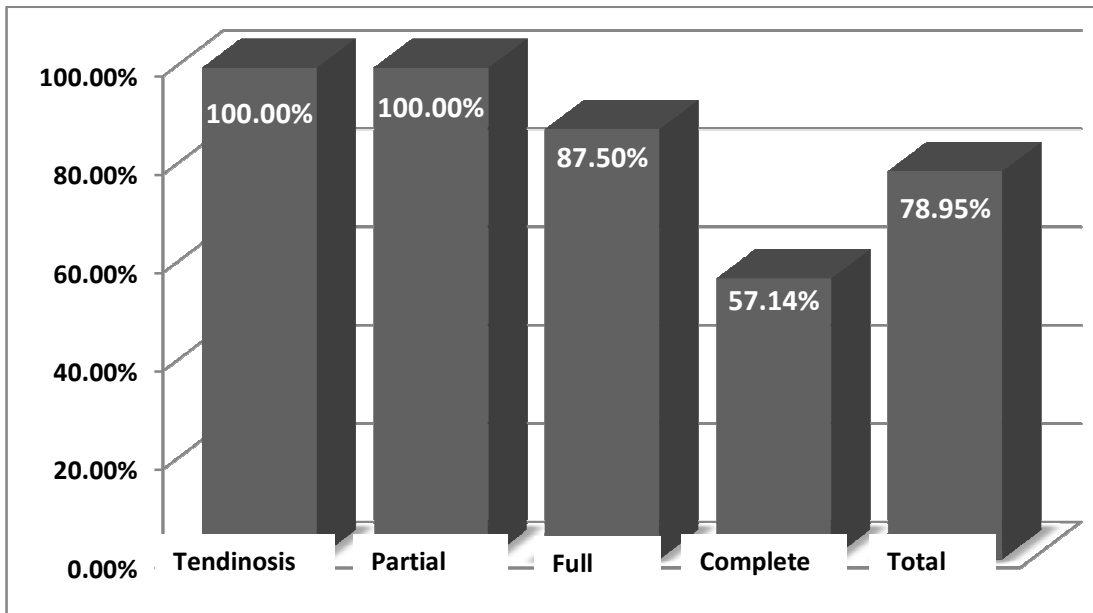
Ultrasound diagnosis of tendinosis, partial thickness tear, full thickness tear, and complete tear with surgical correlation
